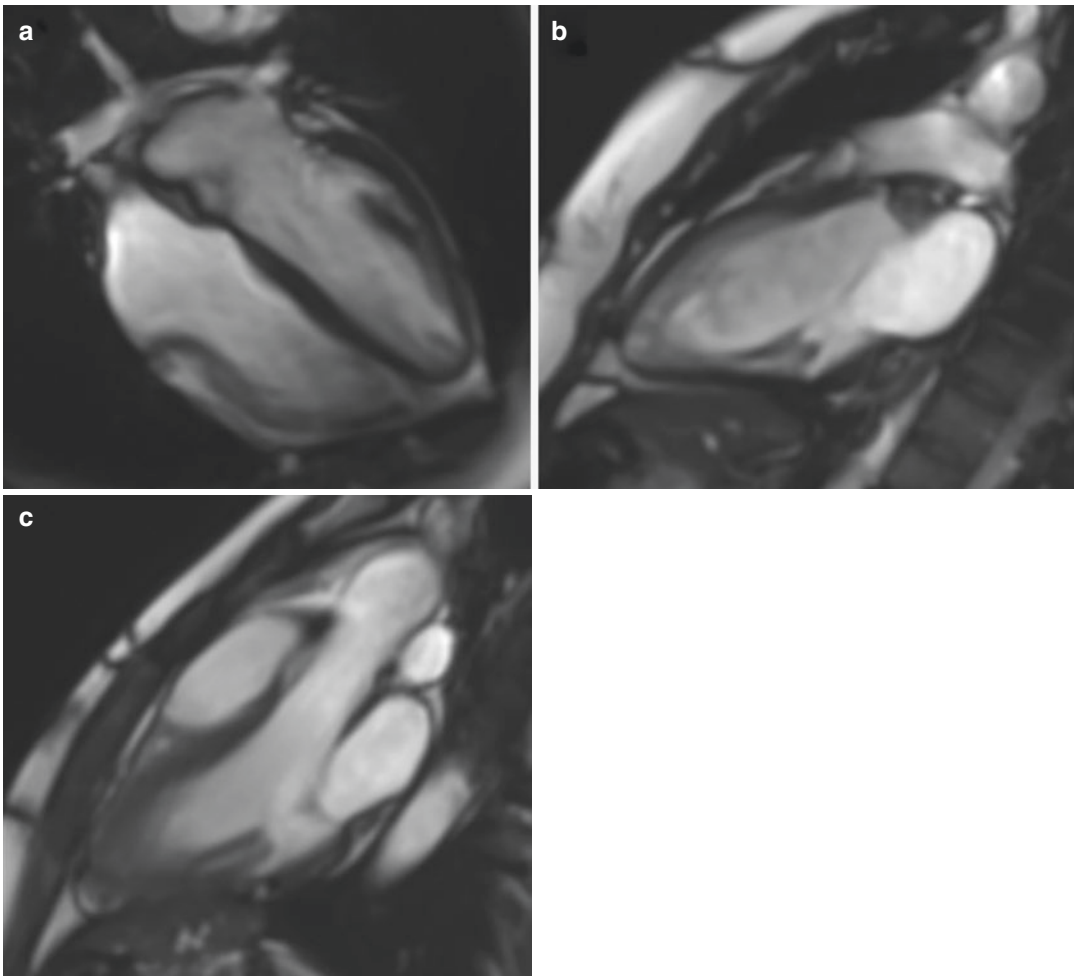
The application of CMRI for measurement of left ventricular ejection fraction (a). Apical four chamber (b). Two-chamber view (c). Three-chamber view. (Imaging from our institution)
